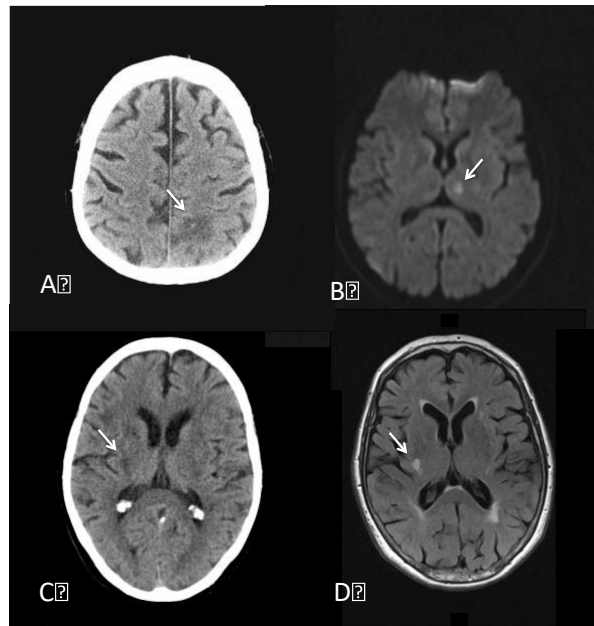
Acute ischemic stroke (arrows) shown by computerized tomography imaging (CT) (A, C) and MRI (B, D). Medium-sized infarct in the left posterior parietal cortex (A), small left thalamic infarct (B). Small right striatal infarct of the same patient imaged by CT (C) and MRI (D). Note that images are viewed by clinical convention (patient lying in horizontal resting position and viewed from caudal direction, i.e., left side in the image represents the right side of the brain.)
